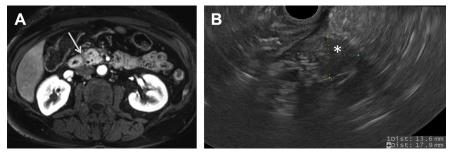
(A) Axial MRI showing a 1-cm heterogeneous mass in a 57-year-old woman with recurrent pancreatitis (arrow indicates mass). (B) EUS of this patient confirming a 13.6×17.9 -mm mass in the head of the pancreas. Surgical resection was performed and pathologic findings confirmed GP. The patient's recurrent pancreatitis symptoms resolved. Asterisk indicates mass.
